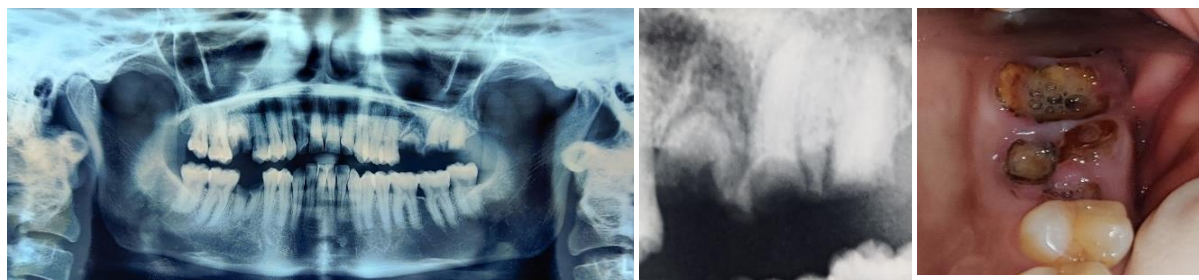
Pre-operative radiographs and clinical view
